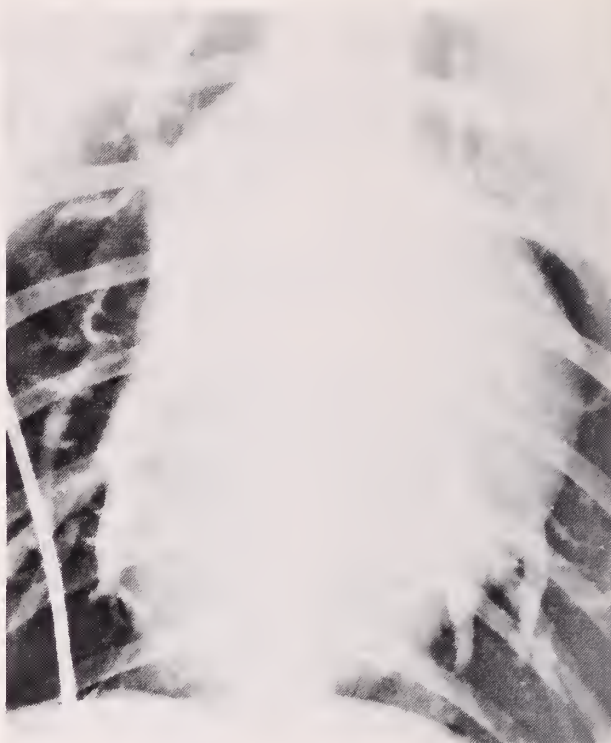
The radiographic appearance (in antero posterior view) after injection of 1 ml per kg of tantalum labeled homologous clot is shown. Lobar and some smaller pulmonary arteries are rather uniformly filled with emboli. The position of the clots generally shows no definite change during 4 hours of perfusion though the condition of the subject improves markedly.
